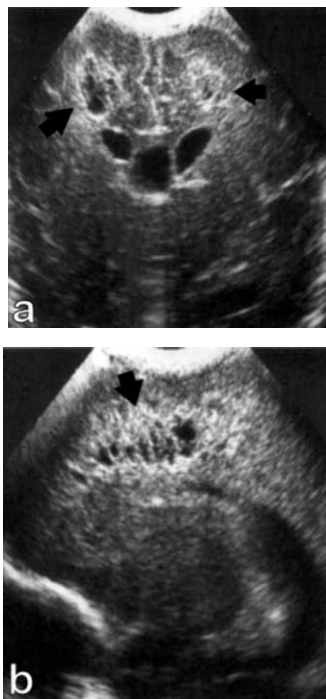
a) Frontal ultrasound scan of preterm infant at 6 weeks of age with PVL 3. Note the appearance of cystic formations (black arrows). b) Parasagittal ultrasound scan showing small cysts frontoparietal (black arrow).
